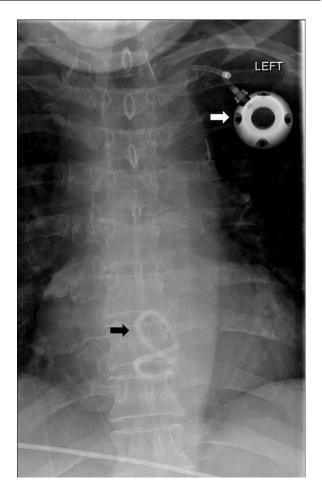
Pre-procedure X-ray showing broken limb of port-a-catheter projecting over cardiac shadow, curled up in figure of eight fashion (black arrow). Port of catheter can be seen projecting over left upper chest (white arrow).
